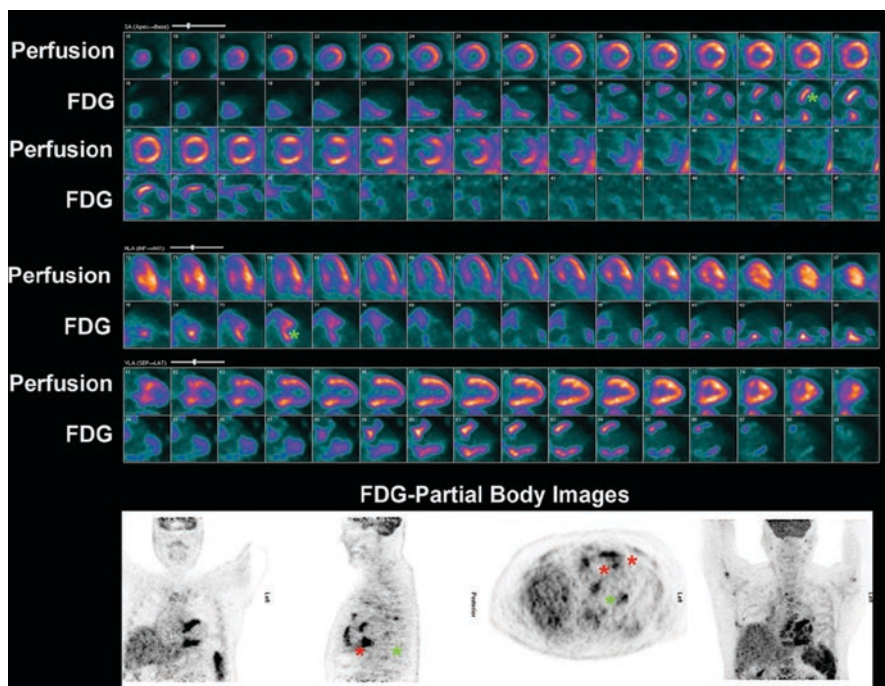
Images from a patient with newly diagnosed cardiac sarcoidosis. Myocardial perfusion images (N-13 ammonia PET) and FDG images are shown in alternate rows. There is a small perfusion defect of moderate intensity in the basal anterolateral wall (best seen on the short-axis images). There are multiple foci of increased FDG uptake in the left ventricular (septum, and anterolateral and inferolateral segments) and right ventricular (free wall) walls. Partial body FDG images are shown below. Red asterisks indicate focus of fibrosis and inflammation in the left ventricular anterolateral wall and the septum. Green arrows indicated focus of inflammation in the right ventricular free wall. *FDG* ^{18}F -fluorodeoxyglucose
